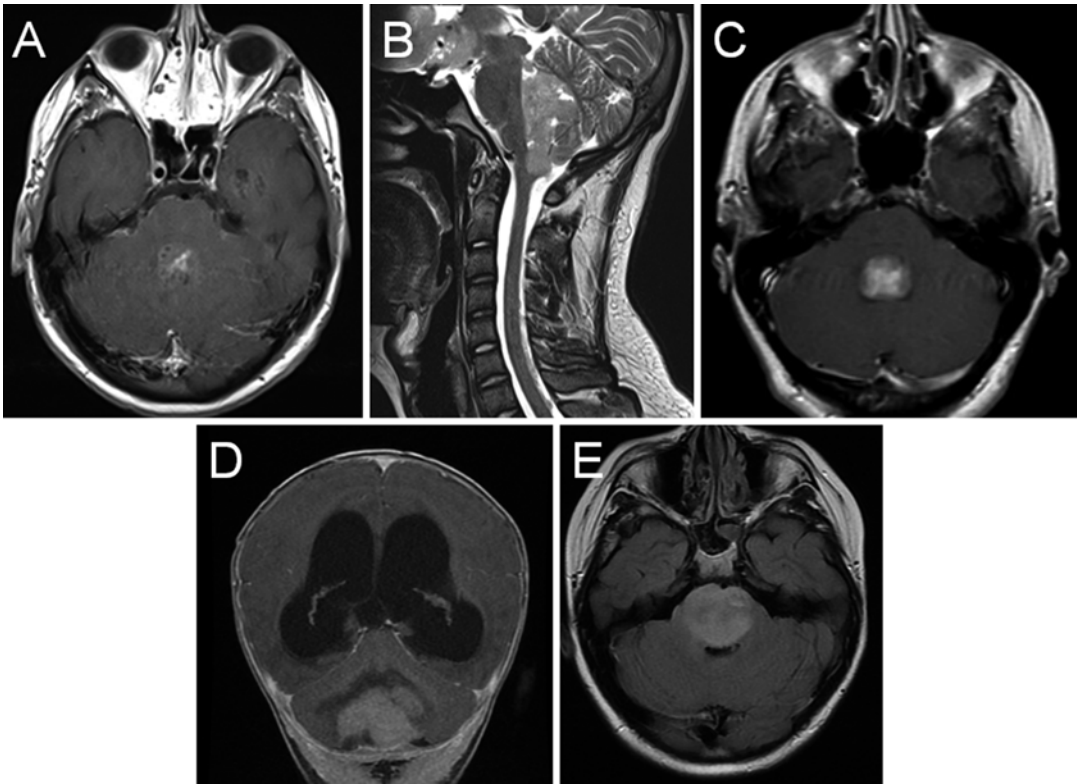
Axial T1 post-gadolinium (a), and sagittal T2 (b) MRI showing a posterior fossa mass lesion with an enhancing component. Surgical resection revealed a medulloblastoma. Axial T1 post-gadolinium (c) shows a
